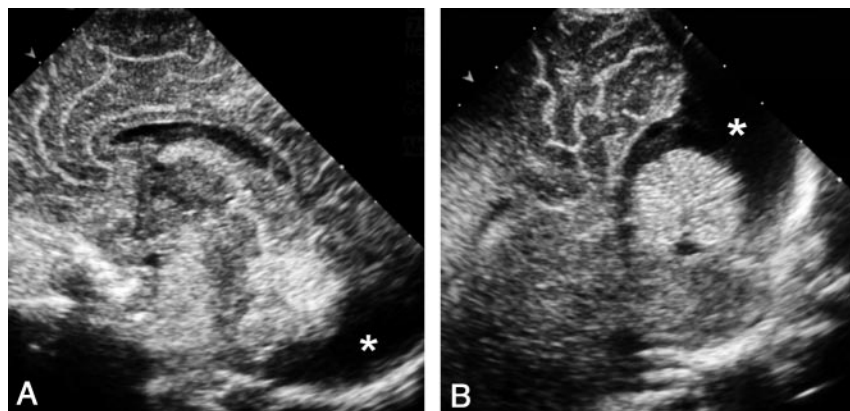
Sonograms obtained in a neonate with a presumptive diagnosis of posterior fossa malformation at prenatal sonography.
